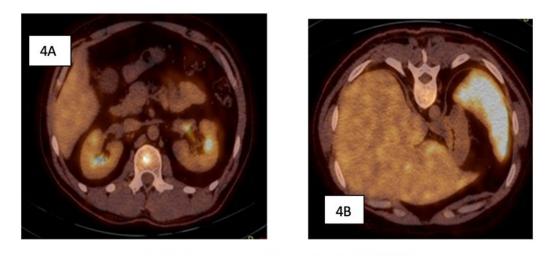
PET/CT and extrapulmonary disease
